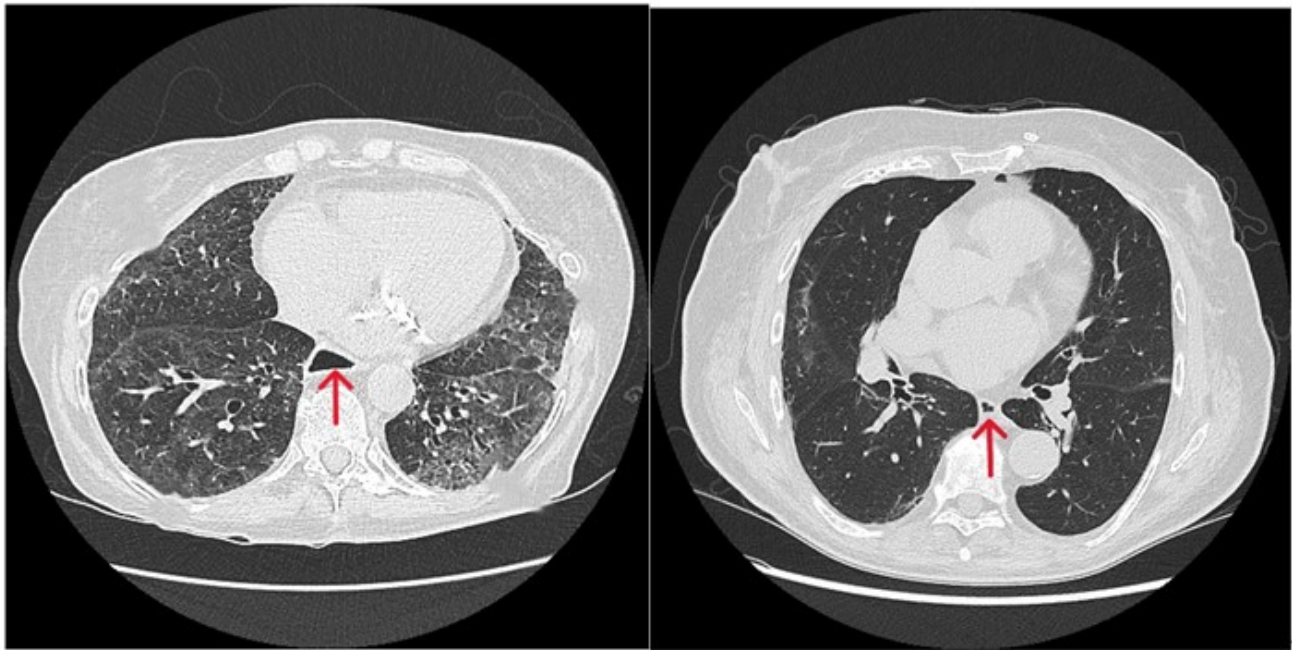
Chest CT comparison of dilated esophagus in scleroderma vs normal esophagus in non-scleroderma. Axial CT of the chest demonstrates a markedly dilated esophagus (arrow, left CT), consistent with advanced esophageal involvement in systemic sclerosis compared to a normal esophagus (arrow, right CT) (Patient permission was not required as no HIPAA information is reported).
